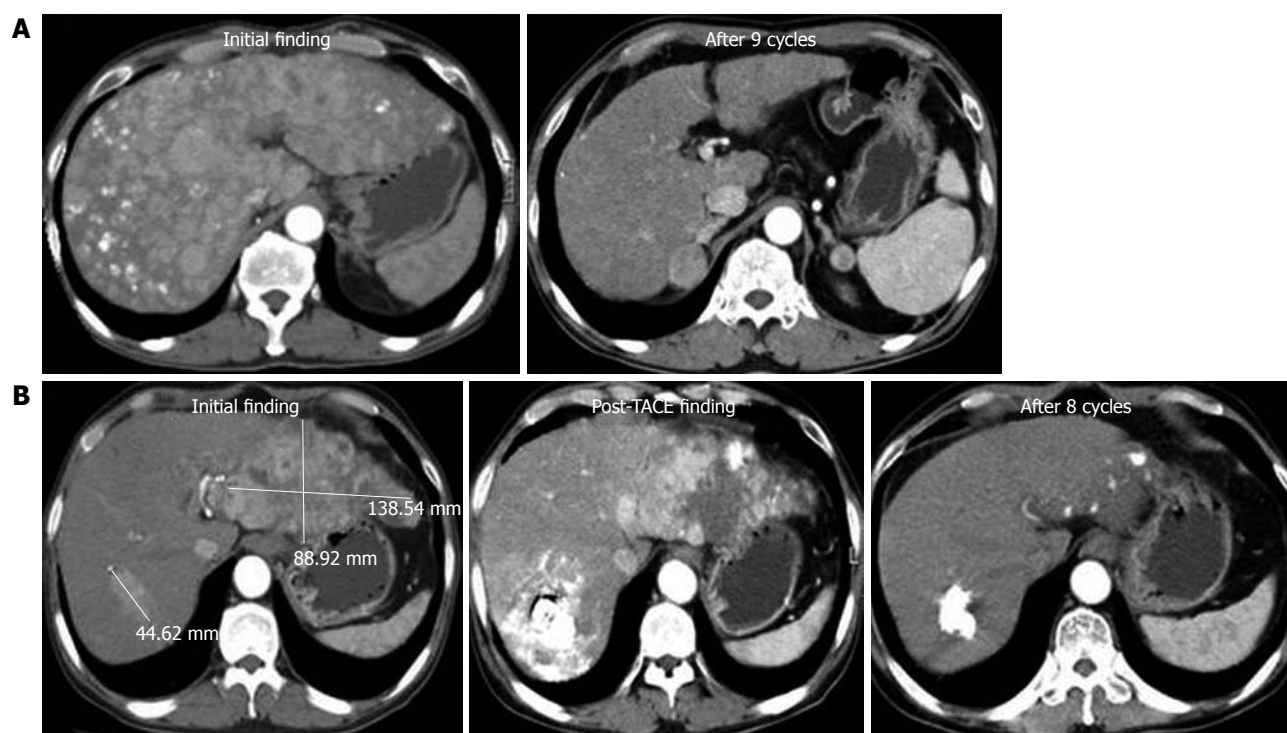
Two cases of nearly complete response. A: The first case was a 54-year-old patient with diffuse, multinodular hepatocellular carcinoma throughout the whole liver. After 9 cycles of hepatic arterial infusion chemotherapy (HAIC) with floxuridine, no enhancing nodular lesions were observed by dynamic contrast-enhanced computed tomography (CT); B: The second case was a 48-year-old patient with a large mass in the left lobe and intrahepatic metastasis in the right lobe. After transarterial chemoembolization treatment, viable masses were still observed in sequential CT images, and HAIC was started. After 8 cycles of chemotherapy, no viable masses were observed. TACE: Transarterial chemo-embolisation.
